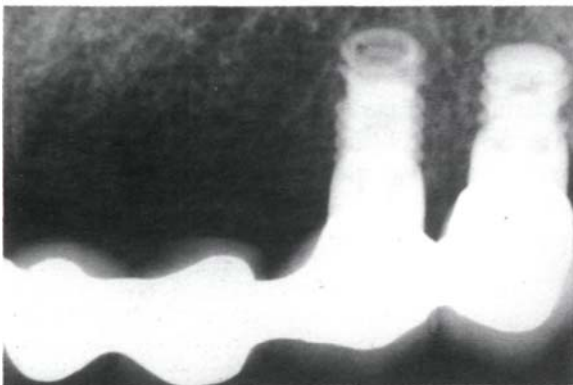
Post operative peri-implant zone radiograph with bridge placed on.
